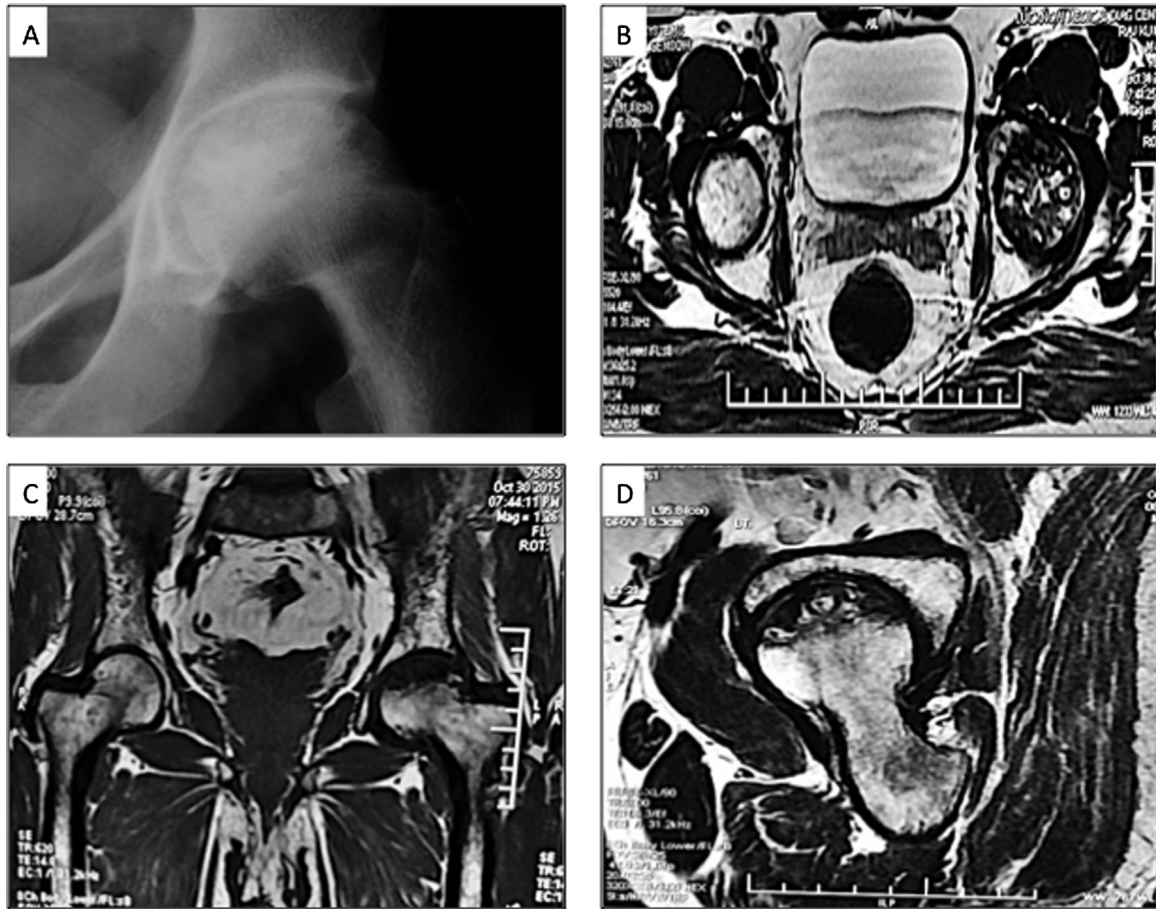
(A) Plain X Ray showing left femoral head with geographical appearance with mixed sclerotic and lucent areas, representing AVN related changes (B) MRI T1WI showing irregular articular surface of left femoral head with marked flattening and deformation. Left femoral head sub articular region shows 'crescent sign' (C) T2WI Left hip joint space is markedly reduced with sub articular sclerotic changes in acetabulum (D) T1WI showing signal intensity changes suggestive of edema, noted in acetabulum, head and neck of femur.
